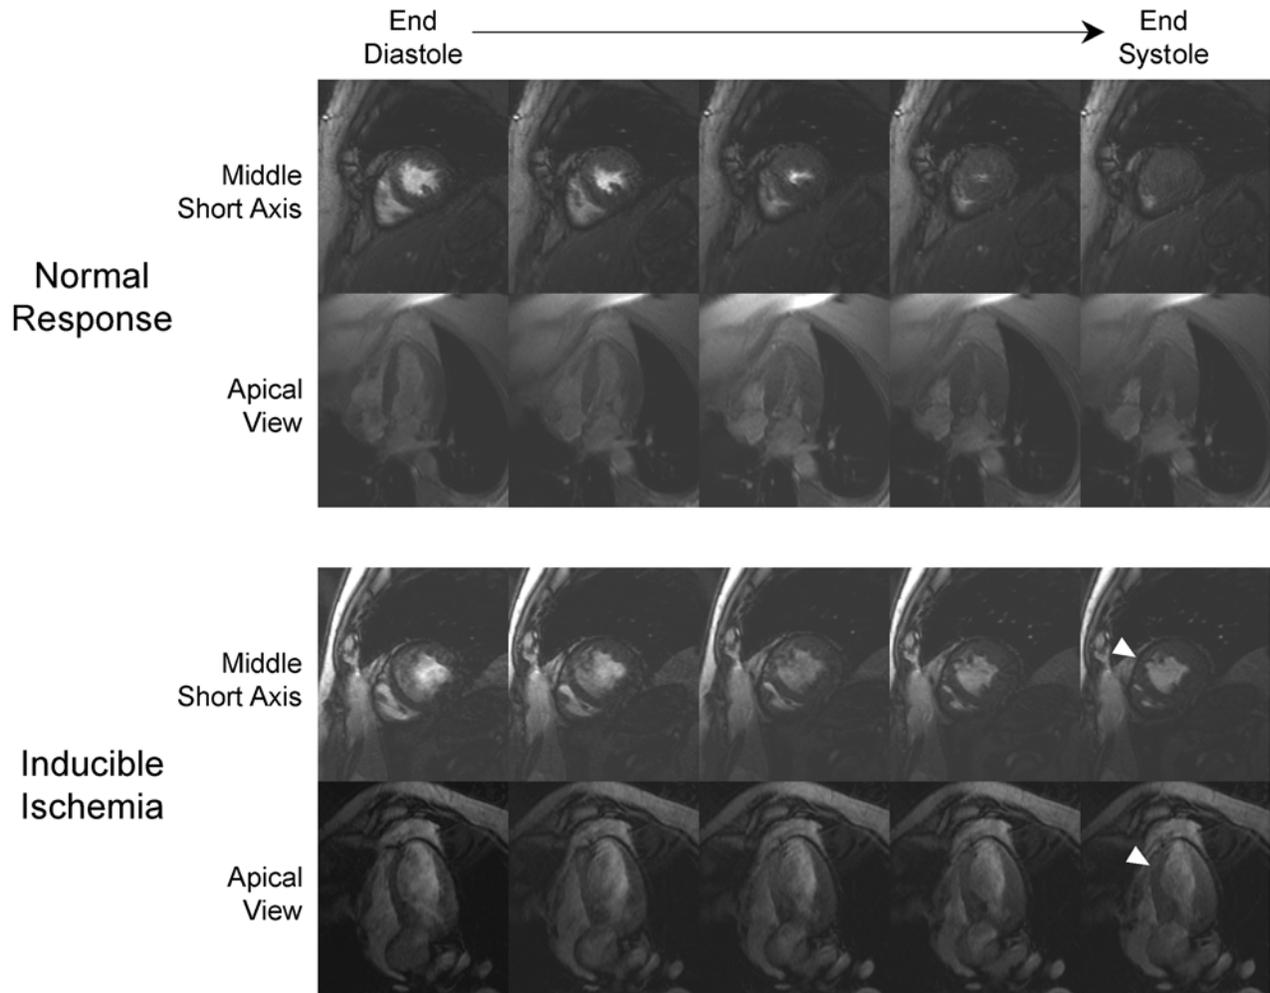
Peak Dobutamine infusion cine MR images of the left ventricle (LV) are shown in the middle short axis and the apical LV outflow tract views. Several images from end diastole (left) to end systole (right) are displayed in a patient with a normal contractile response (top panels), and evidence of inducible ischemia (bottom panels). Inducible ischemia is identified by the development of hypokinesis in the middle and apical segments of the anteroseptum at end systole (white arrows).
